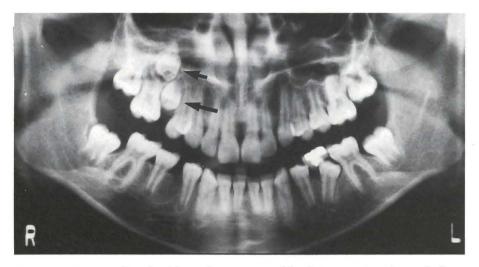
Unerupted tooth #15 in a fourteen-year-old girl. Panoramic radiograph shows two impacted permanent second premolars one above the other. The precise morphology of their crowns and roots is unclear.
